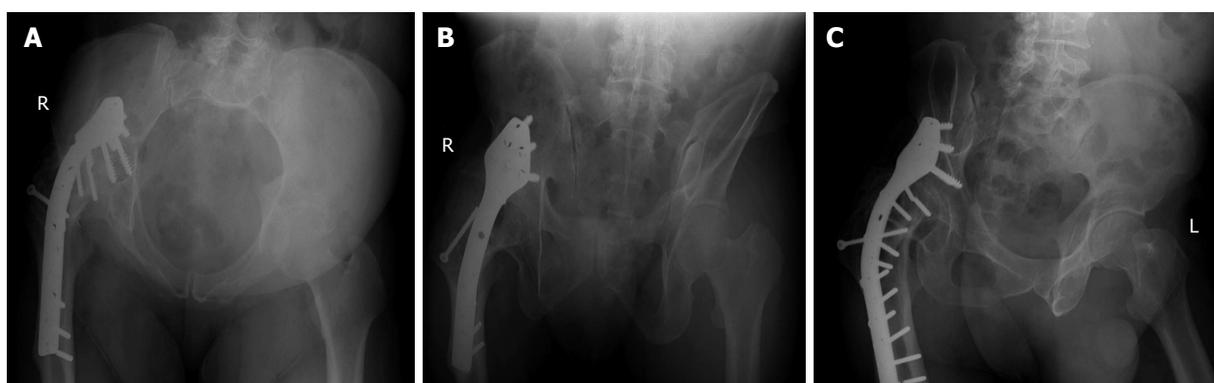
Radiographs at 5-mo follow up which revealed broken screws (A and B) and further loosening (C).
